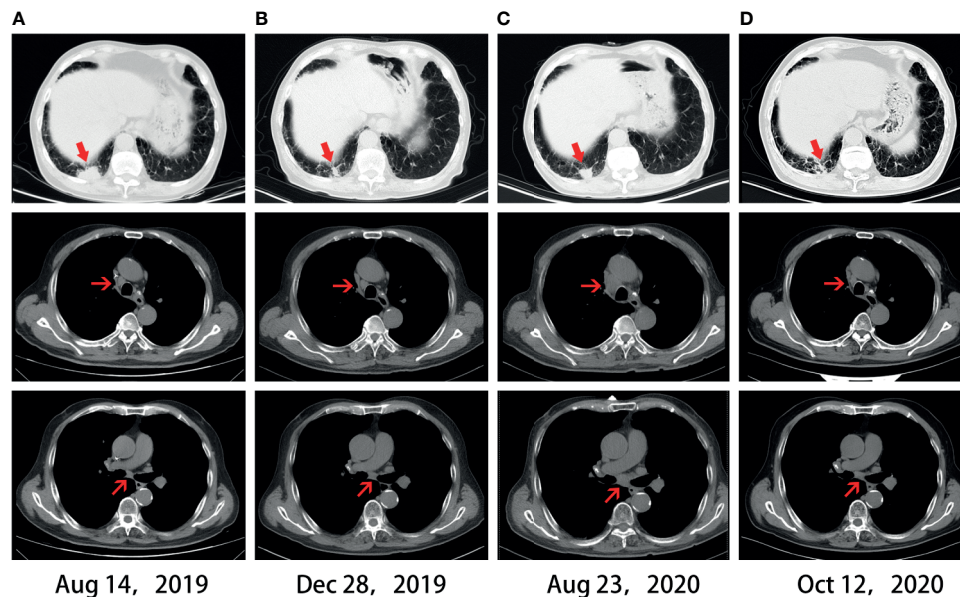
Chest CT scans. (A) CT before immunotherapy. (B) CT revealed a partial response after four months of immunotherapy. (C) CT revealed disease progression after acquired resistance of immunotherapy. (D) CT revealed an abscopal effect after one month of local ablation.
